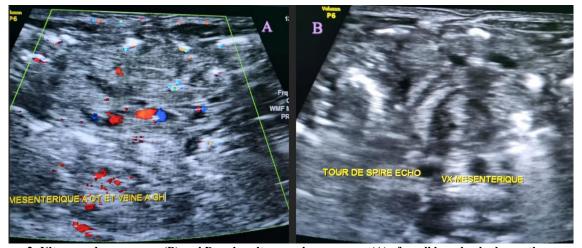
Ultrasound appearance (B) and Doppler ultrasound appearance (A) of small bowel volvulus on the common mesentery
